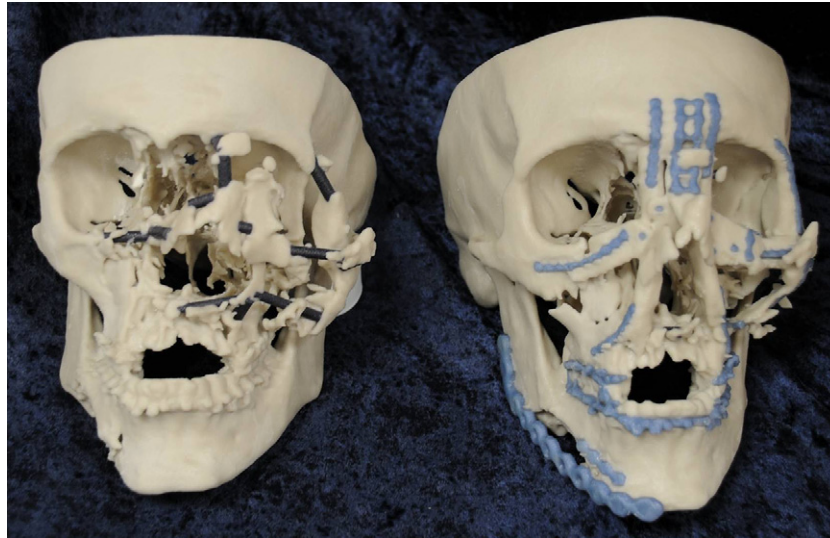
Additive manufactured models from CT scans, before and after surgical reconstruction.
